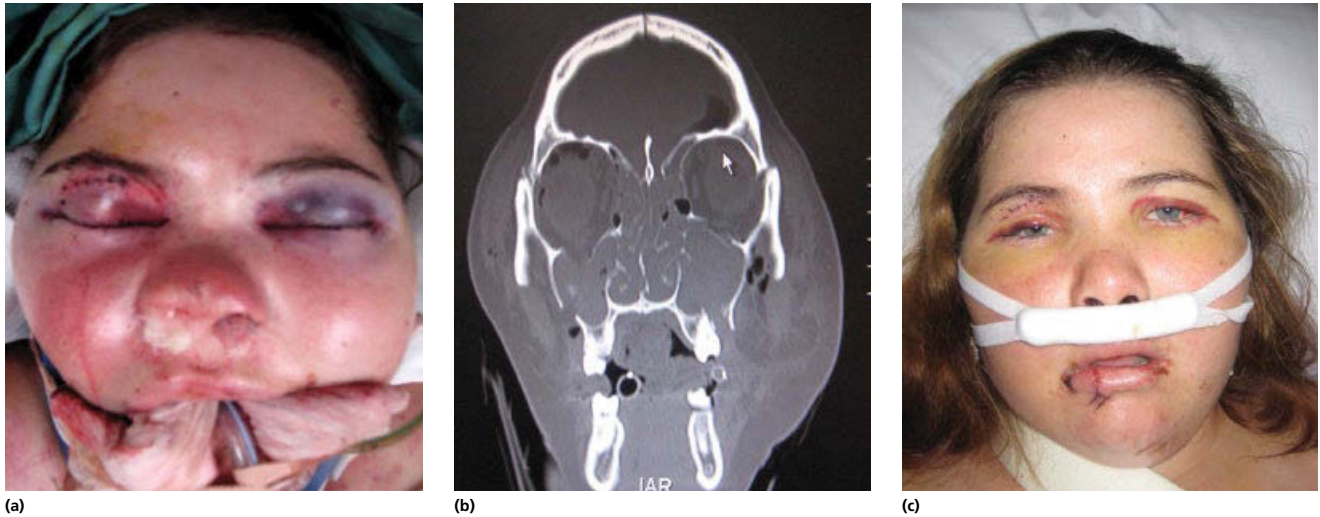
A patient with fractures at all three Le Fort levels. (a) Swollen, bruised, nasal and oral packing to control haemorrhage, and intubated to protect her airway. (b) The coronal CT slice shows the endotracheal tube, the oral packing and the fractures. (c) After 7 days, extubated, lacerations sutured, swelling abating, clinically there is right enophthalmos, flattening of the cheeks, flattening and widening of the nasoethmoid region and an anterior open bite.
